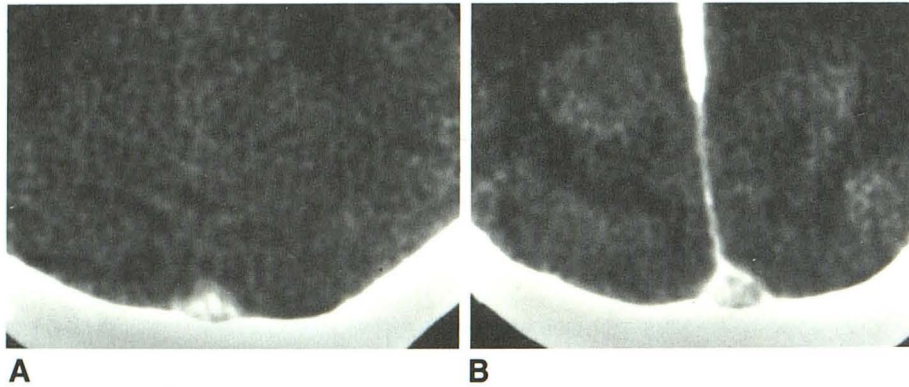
Pre- (A) and postcontrast (B) CT images of superior sagittal sinus in a patient with angiographically proved acute sinus thrombosis.
